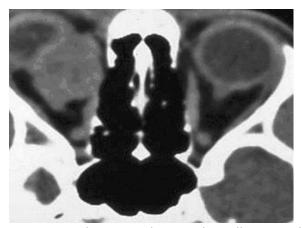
Axial CT image shows a rather well-circumscribed homogeneous mass, isodense to the extraocular muscles in the superior portion of the right orbit.
